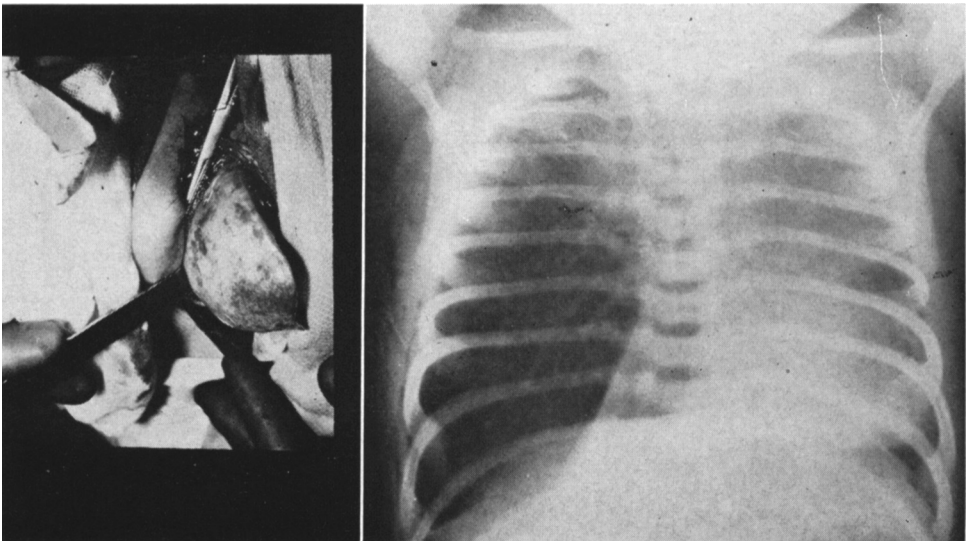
Right*, Roentgenogram of markedly emphysematous right middle lobe, with displacement of heart to left. *Left*, Photograph made at operation; the emphysematous lobe protrudes markedly through the operative wound.
